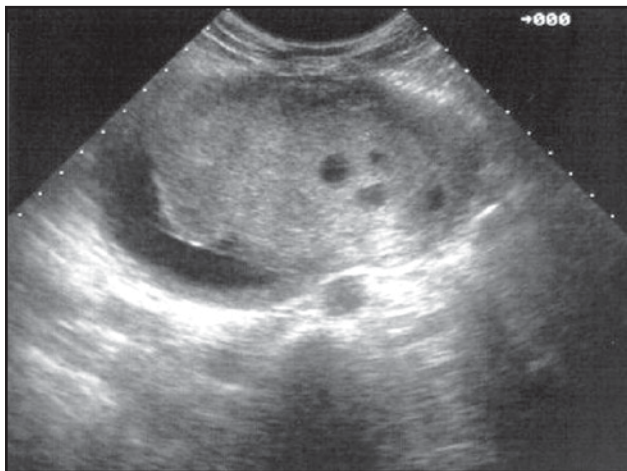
Sonogram of a hydatidiform mole (molar pregnancy). Note the grape-like structures within. Image from the author's teaching files.
